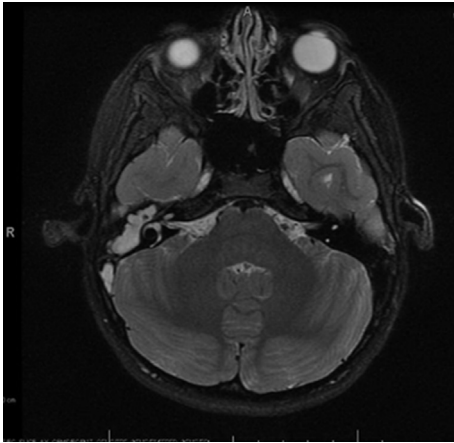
T2-weighted axial non-contrast MRI with hyperintense right-sided mass.
